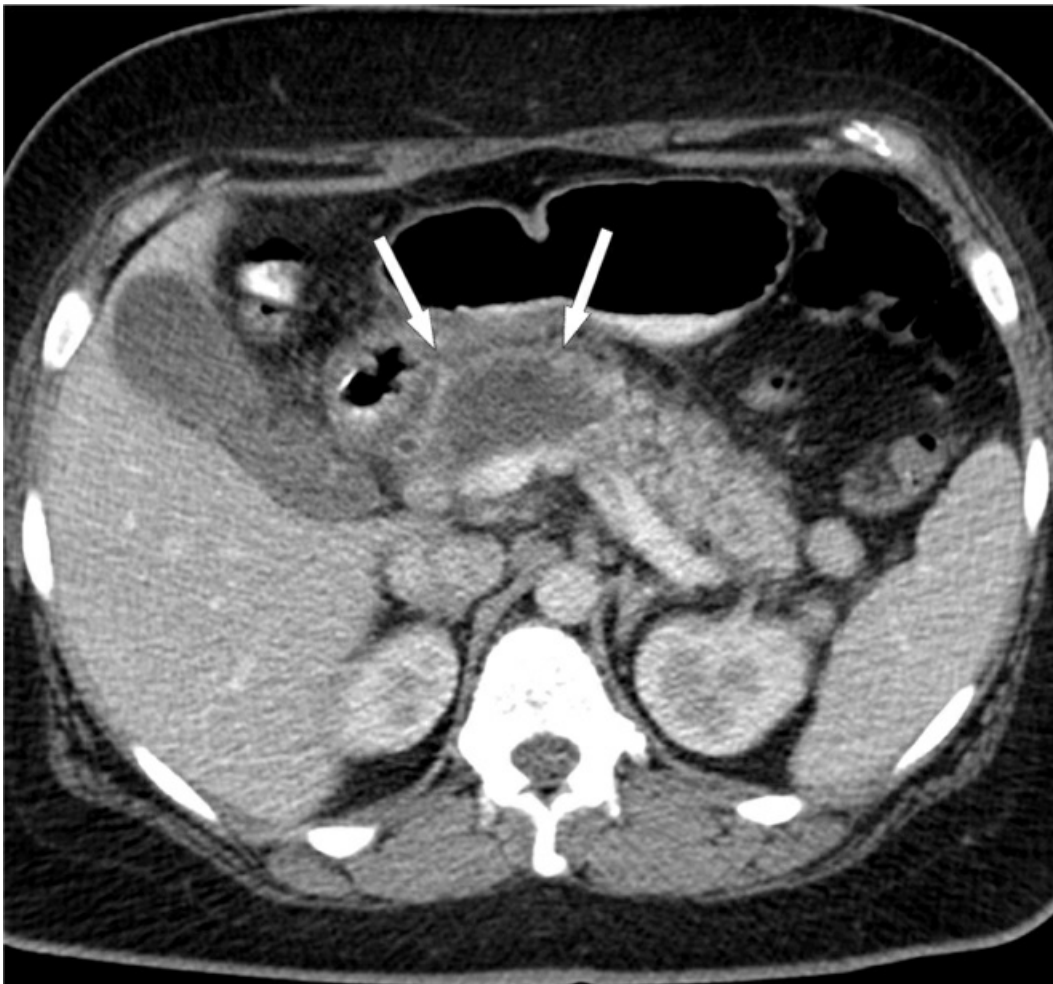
Contrast-enhanced CT image showing necrotizing pancreatitis. The area that is not contrast-enhanced (indicated by the arrows) represents necrosis in the neck and body of the pancreas. Image from Reference 8.
